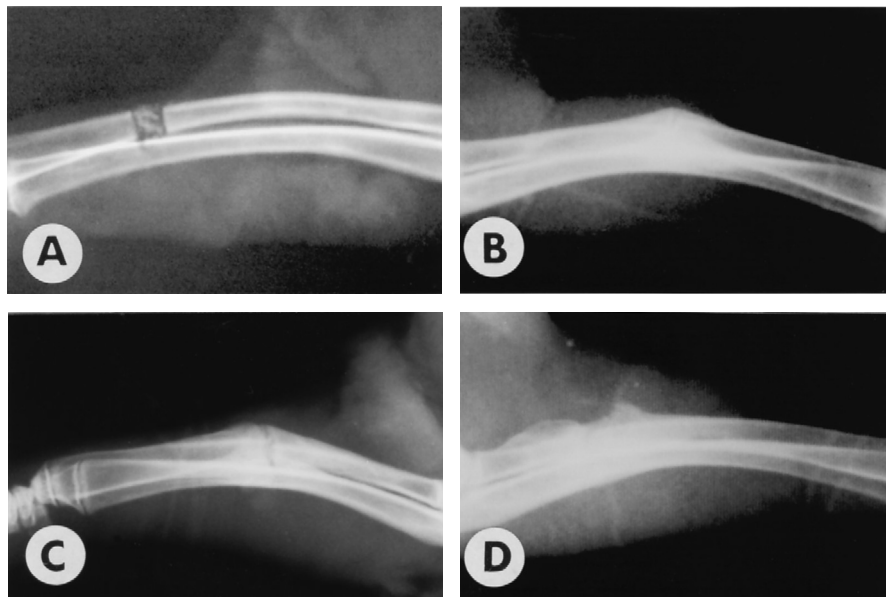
Roentgenograms show the appearance of the bone allografts at 2 days after surgery (A), then pasteurized (B), frozen (C) and autoclaved (D) grafts at 4 weeks after implantation.
